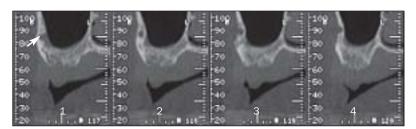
Transversal view of a left sinus on a CT scan: variations of the artery's position in the external wall of the sinus. (1) The artery is not seen from the schneiderian membrane. (2) The artery is intraosseous. (3 and 4) The artery has a subperiosteal position.
